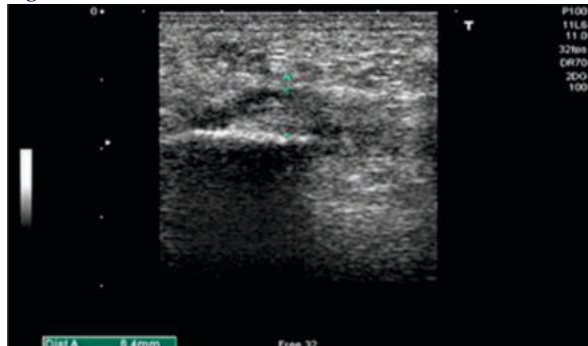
Ultrasound Of Plantar Fasciitis Showing Hypoechoic, Thickened Fascia.
